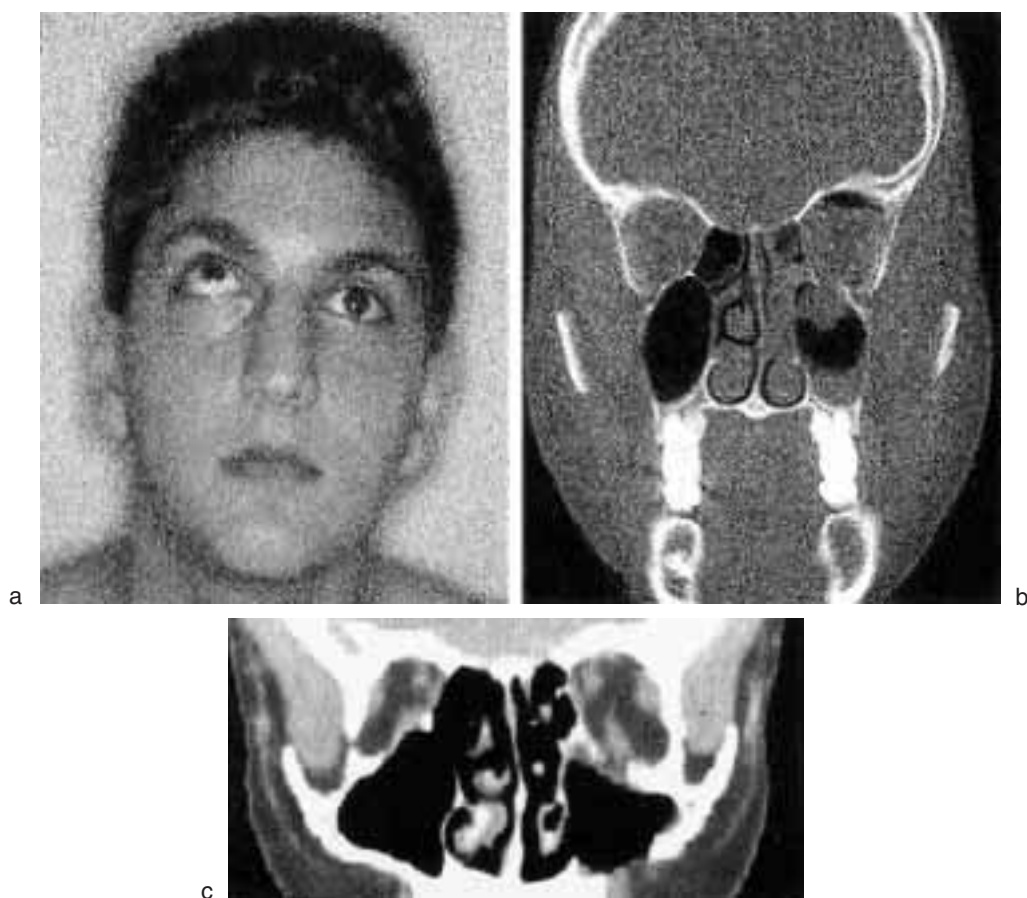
Deficit in elevation of left ocular bulb due to entrapment of inferior rectus muscle (a). Coronal CT reveals isolated fracture of orbital floor (blow-out) with herniation of orbital content into the maxillary sinus (b). CT after fracture reduction, prolapsed orbital tissue elevation and bone defect in the orbital floor covered with silastic sheet (c). Surgery was carried out by cutaneous, infraorbital incision.
